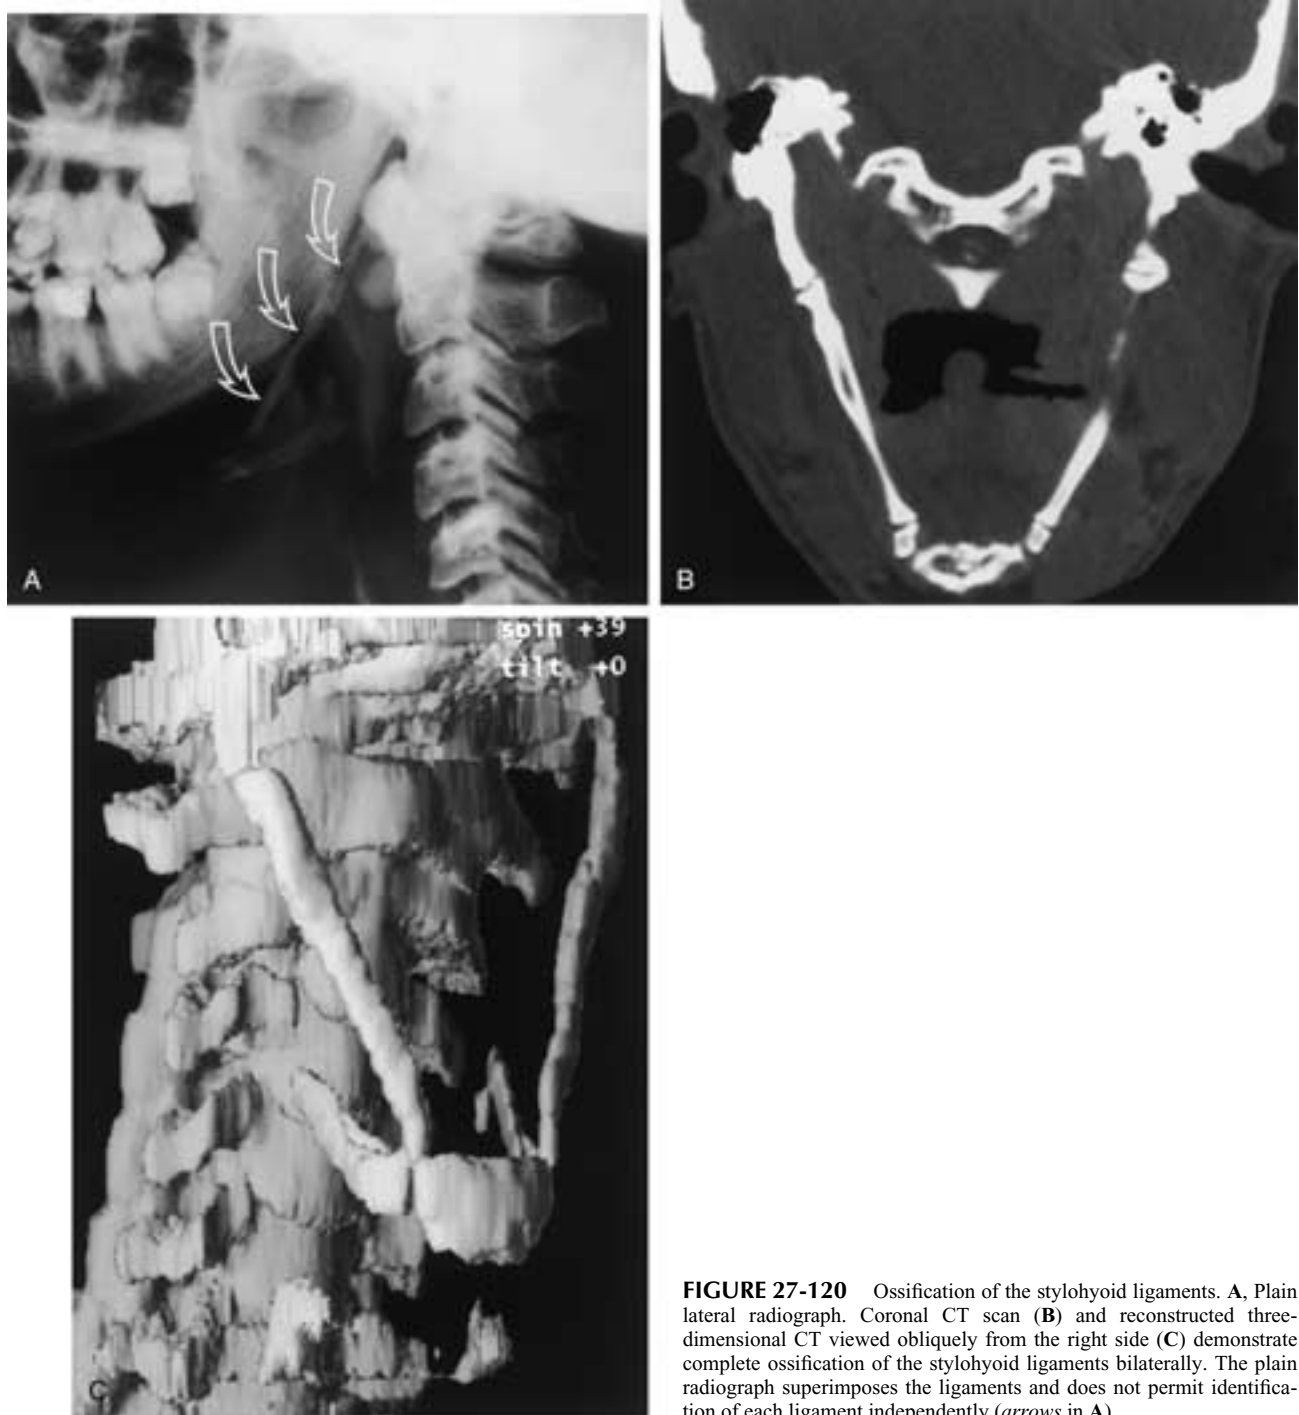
Ossification of the stylohyoid ligaments. A, Plain lateral radiograph. Coronal CT scan (B) and reconstructed three-dimensional CT viewed obliquely from the right side (C) demonstrate complete ossification of the stylohyoid ligaments bilaterally. The plain radiograph superimposes the ligaments and does not permit identification of each ligament independently (*arrows* in A).
